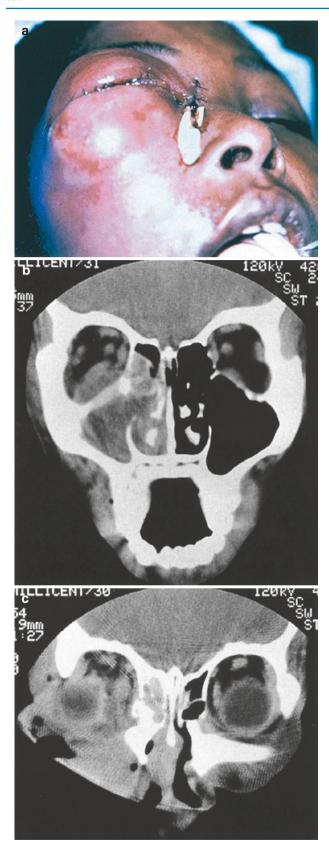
Orbital abscess. (a) Intraoperative photo of right orbital abscess. (b) CT scan of this patient when the infection was confined to a subperiosteal abscess. (c) CT scan 4 days later when the infection has spread to the orbital tissues
